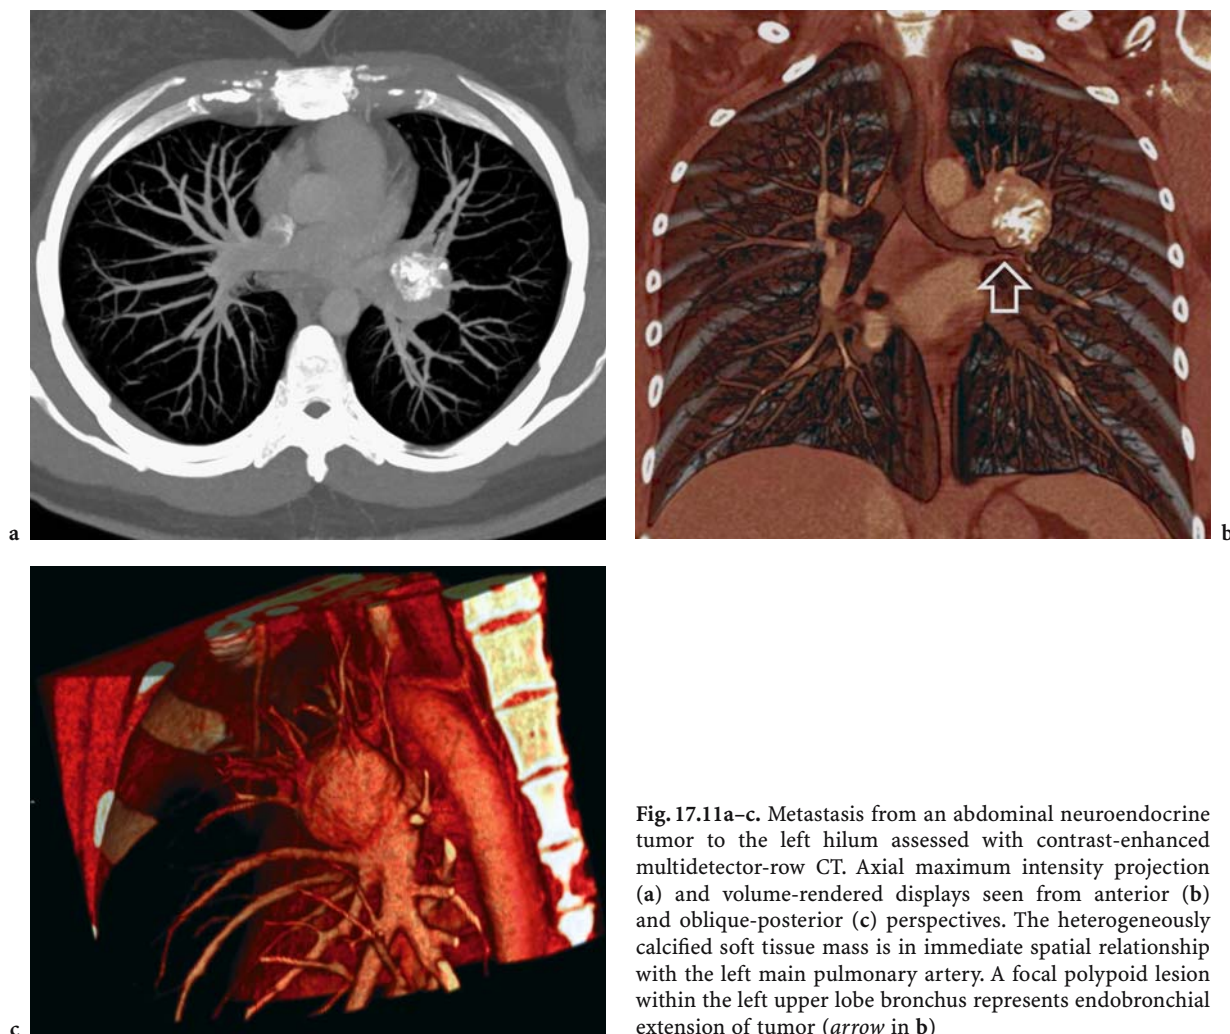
Metastasis from an abdominal neuroendocrine tumor to the left hilum assessed with contrast-enhanced multidetector-row CT. Axial maximum intensity projection (a) and volume-rendered displays seen from anterior (b) and oblique-posterior (c) perspectives. The heterogeneously calcified soft tissue mass is in immediate spatial relationship with the left main pulmonary artery. A focal polypoid lesion within the left upper lobe bronchus represents endobronchial extension of tumor (arrow in b)
